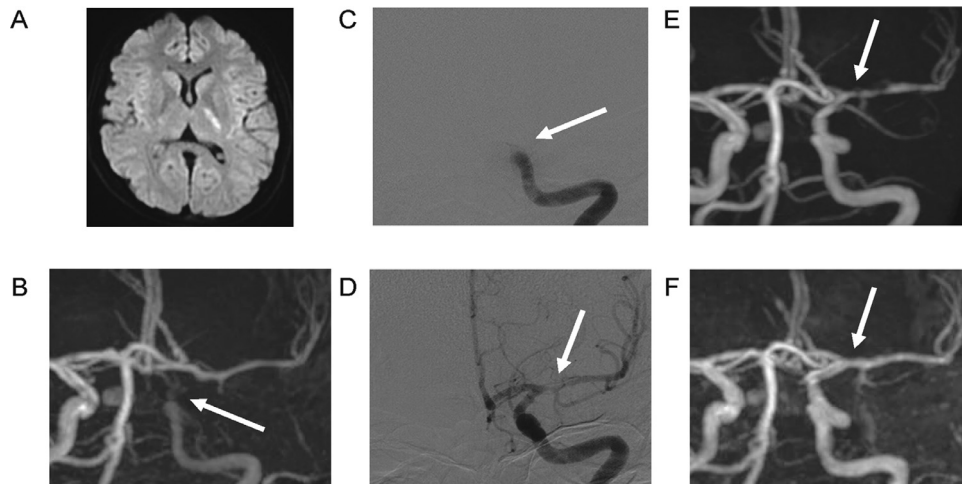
(A) Head diffusion-weighted magnetic resonance imaging at symptom onset showing a high intensity area in the left posterior limb of the internal capsule. (B) MRA before the rt-PA/EMT treatment also showing occlusion of the left ICA. (C) Angiography before EMT shows an occlusion of the left ICA. (D) Angiography after EMT showing recanalization of the left ICA and stenosis of left M1 segment. (E) MRA on day 9 showing the remaining stenosis of the left M1 segment. (F) MRA on day 106 showing that the stenosis had disappeared. Abbreviations: EMT, endovascular mechanical thrombectomy; ICA, internal carotid artery; MRA, magnetic resonance angiogram; rt-PA, recombinant tissue plasminogen activator.
